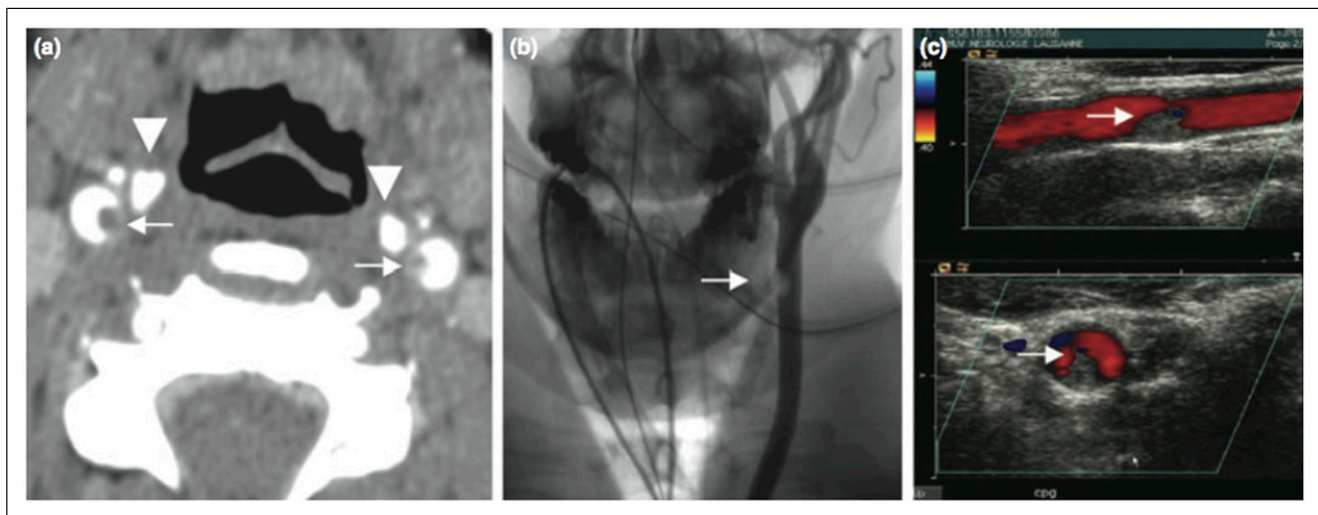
Case no. 2. Bilateral hyoid-carotid conflict, with the publisher's authorisation: “(A) CT angiography, showing two symmetrical endoluminal defects along the posterior-medial aspect of the common carotid arteries (CCA) (arrows), at the level of the hyoid bone (arrowheads). (B) Digital subtraction angiography, left CCA injection, anteroposterior view, confirming the presence of a spherical filling defect within the distal CCA (white arrow). (C) Duplex sonography, longitudinal (top) and axial (bottom) views, depicting the endoluminal lesions (white arrows)”.
